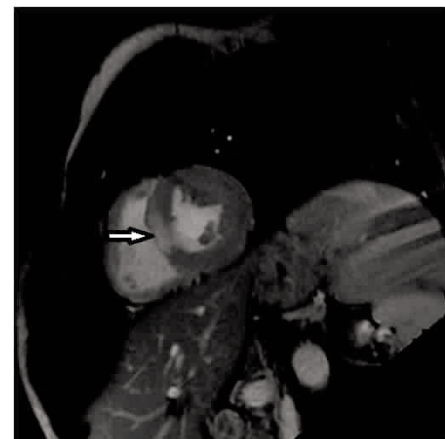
Acute myocarditis in 38-year-old male presenting with acute chest pain. SSFP-Cine MRI before injection and T2-weighted STIR. (spontaneous hypersignal= white arrow)
